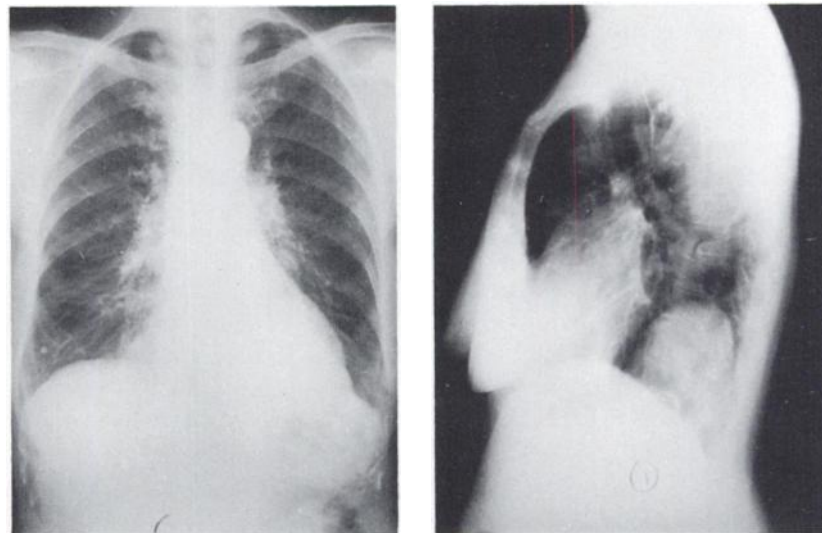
Conventional PA and lateral roentgenogram of chest mass to be located in posterior portion of chest.
